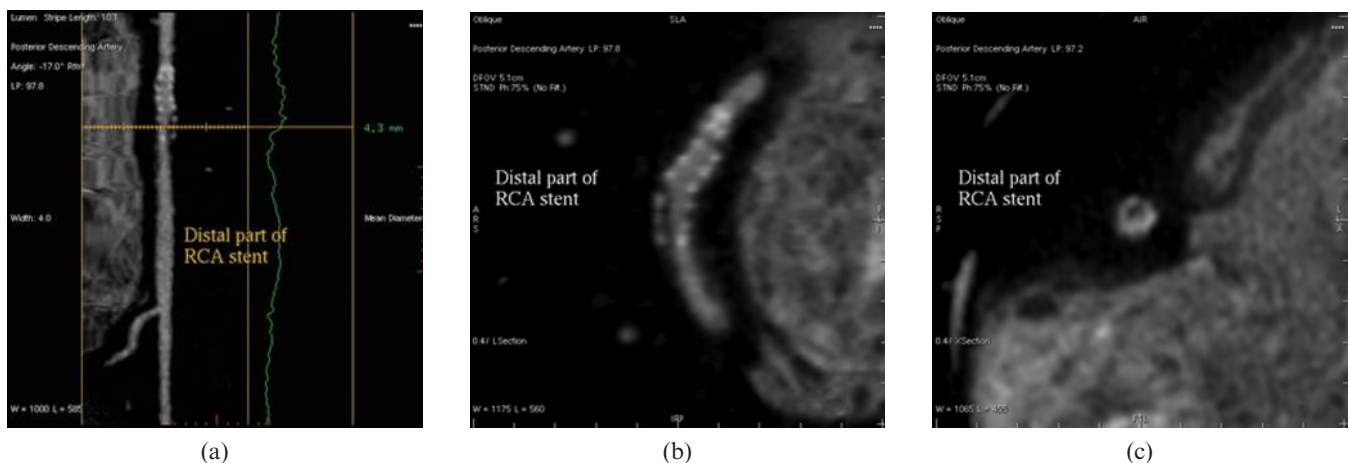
Coronary CT angiography of in-stent restenosis. An in-stent restenosis is present at the distal part of the right coronary artery (RCA) stent which is demonstrated as the low-attenuating area on longitudinally straightened (a), curved multiplana reformatted (b) and cross-sectional images (c).
